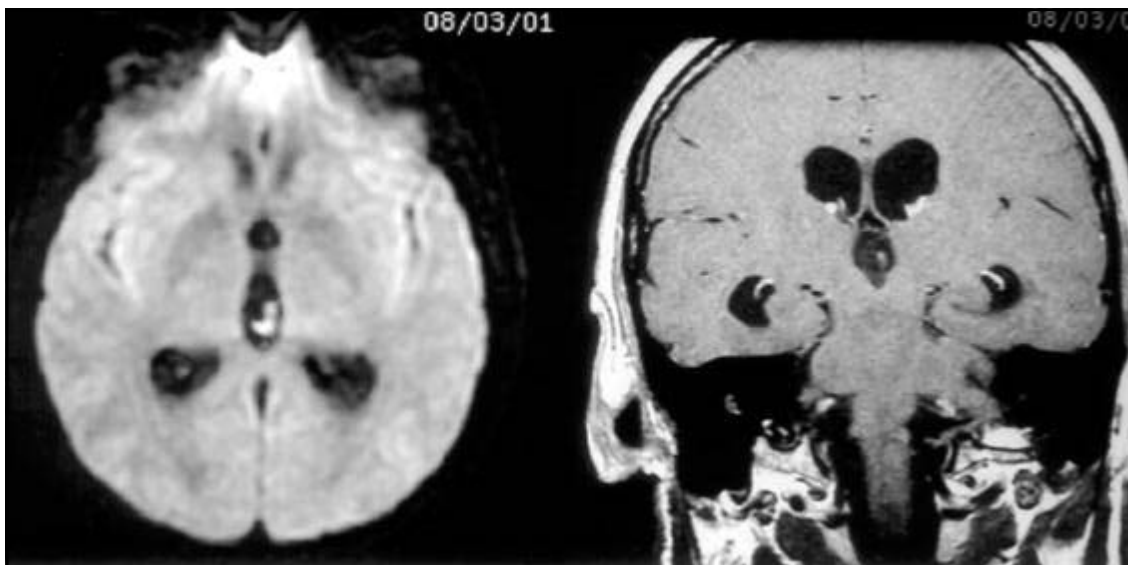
MRI - Axial Diffusion and Coronal T1WI 3mm thick slices postcontrast (Gd-DTPA): Cysticercus in the third ventricle. This lesion was not visible on the other sequences.
